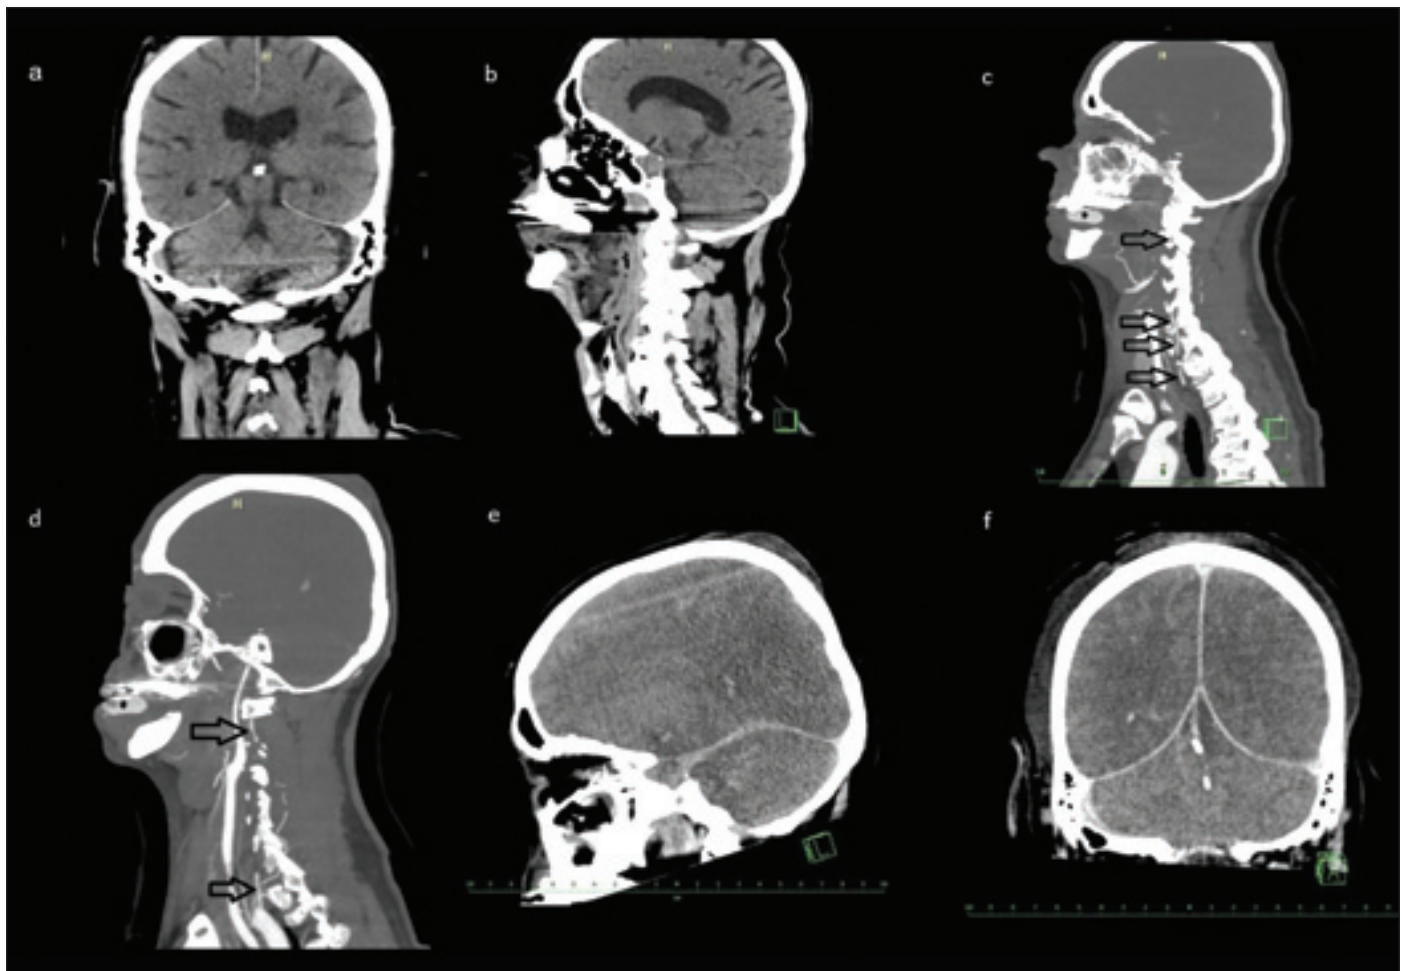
Initial brain CT scans taken upon the patient's admission in the coronal (a) and sagittal planes (b) reveals early cerebral edema. (c) A sagittal CTA scan of the patient's left side. This image demonstrates an absence of contrast filling during angiographic examination of the left vertebral artery. The light gray area represents a patent artery, with the arrow indicating dissection, and the darker gray color depicts artery collapse and no blood flow to the brain. (d) Sagittal CTA scans of the patient's right side, depicting successive cuts of the course of the right vertebral artery. The darker gray color indicates a lack of contrast filling. (e, f) Control CT scan in the sagittal (e) and coronal planes (f) revealed transtentorial and occipital conus herniation and malignant cerebral edema.
